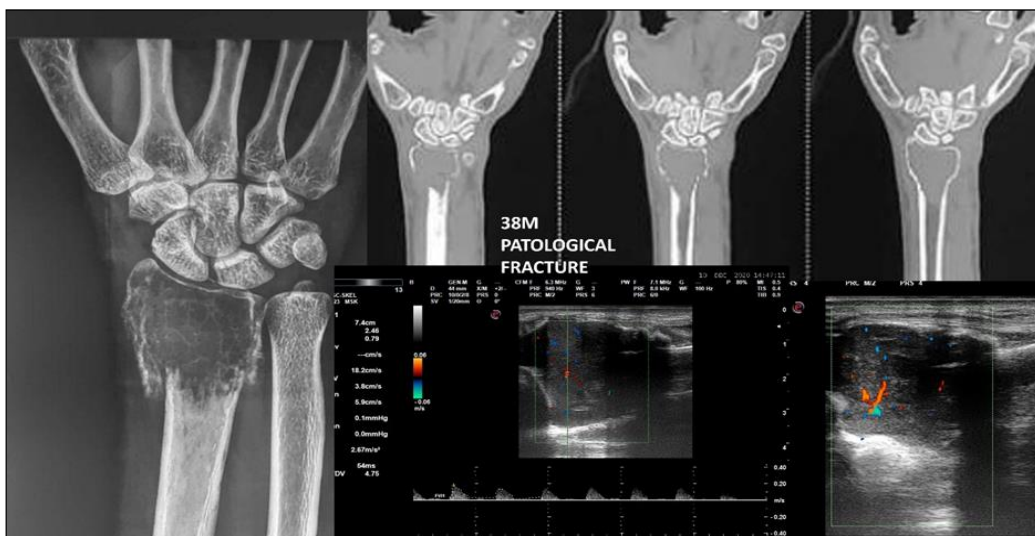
Radiograph and Coronal reconstruction of CT scan reveals expansile lytic lesion with pathological fracture. The cortex and matrix are well seen on CT. On USG there is cystic component in solid hypoechoic lesion and is highly vascular
